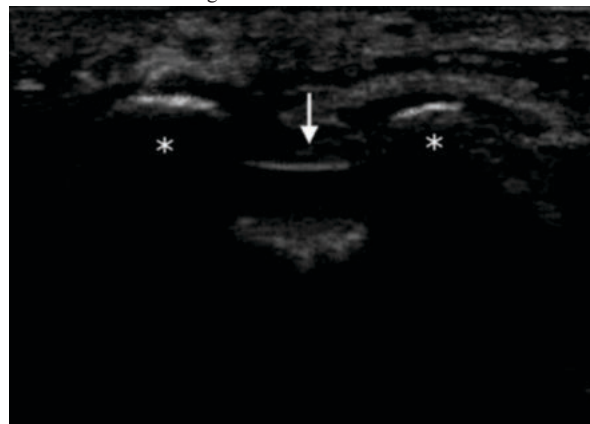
Ultrasound-guided Caudal Block⁷
